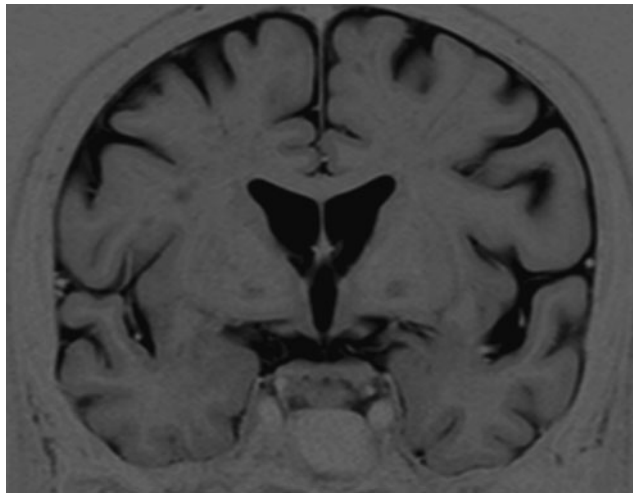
Magnetic resonance imaging true inversion recovery image demonstrating atrophy of the mammillary bodies.
